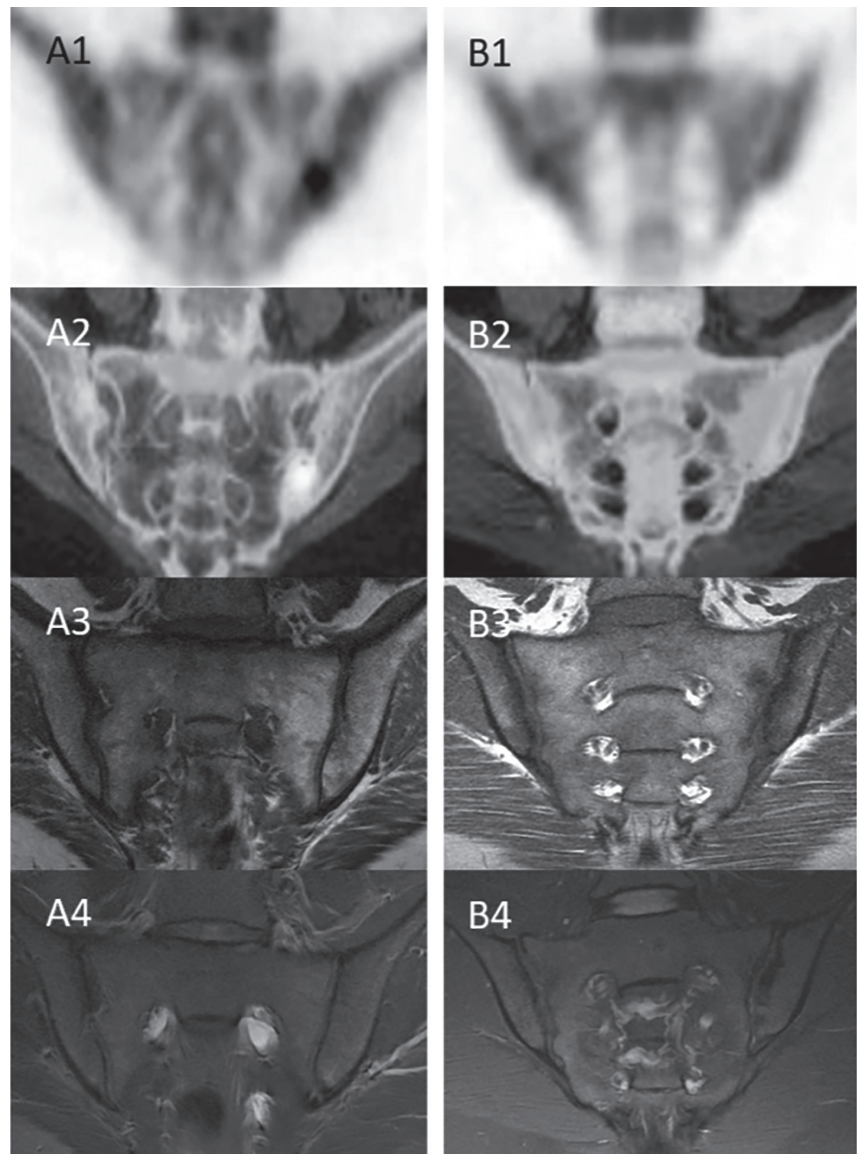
Two examples of discordance between PET/CT and MRI. On figure A1 and A2: a patient with increased NaF uptakes on left SIJ without structural (A3) or inflammatory (A4) SIJ involvement. On figure B3 and B4: a patient with erosion and sclerosis without increased NaF uptakes (B1 and B2)
